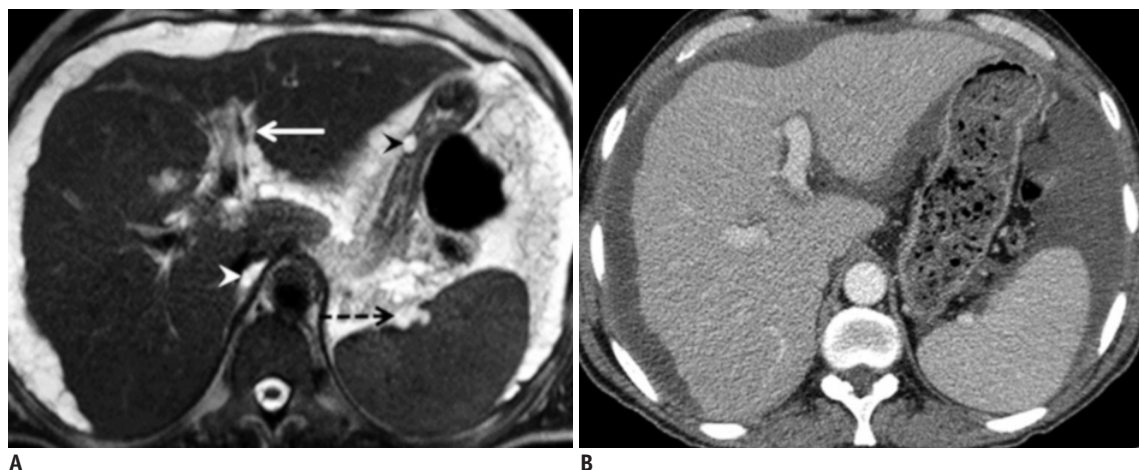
Better depiction of small mucinous implants using MRI than with CT. A 65-year-old male patient with high-grade pseudomyxoma peritonei of appendicular origin. Detection and localization of the mucinous peritoneal lesions are best performed on axial T2-weighted MRI (A) rather than axial contrast-enhanced CT image (B). Of note are the small implants seen on the wall of the lesser curvature of the stomach (black arrowhead, A), behind the inferior vena cava (white arrowhead, A), along the left portal vein (arrow, A), and in the splenic hilum (dotted arrow, A).
